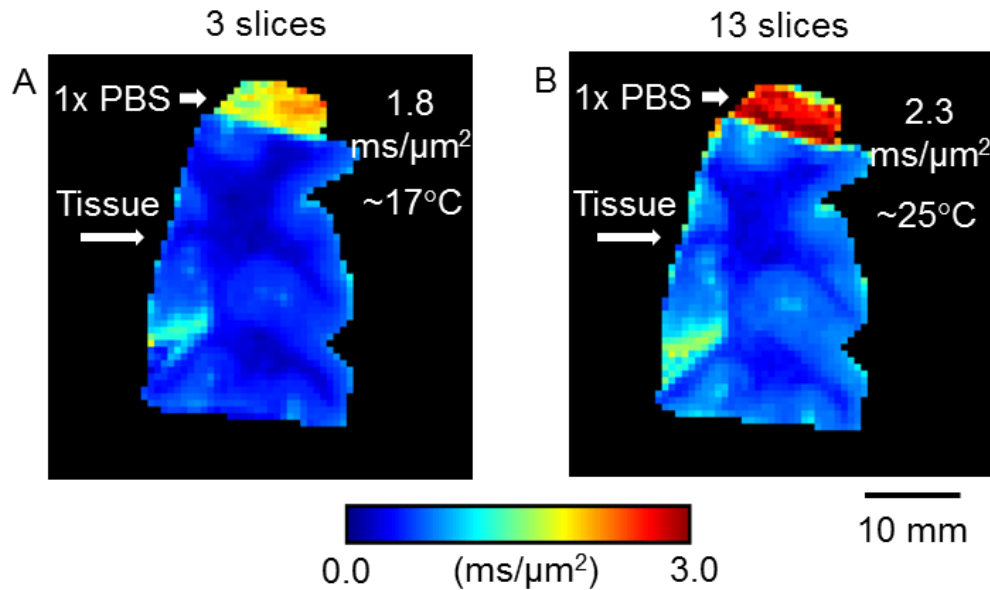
Effects of slice number on diffusivity. A. B. The apparent diffusion coefficient (ADC) maps are shown of data collected using 3 slices and 13 slices, both collected using a b-value of 4 ms/μm². Increasing the number of slices from 3 to 13 results in an average increase in the temperature of 1x PBS by 8° Celsius. This indicates that the number of RF pulses (resulting in the number of MRI slices) affects tissue temperature.
